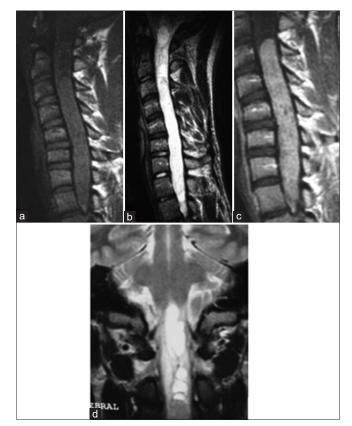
Spinal MRI: A case of Cervico Dorsal Ependymoma. Sagittal section on T1 sequence (a), T2 sequence (b), and T1 after gadolinium enhancement (c); Coronal section on T2 sequence: A tumoral process is centro medullar extended from C3 to D1 (d). This process has an isosignal on T1, it is hyperintense on t2 surrounded by a discreet T2 hypointense line. Enahancement is homogenous. There is an association with syringomyelic cavities and even syringobulbia
